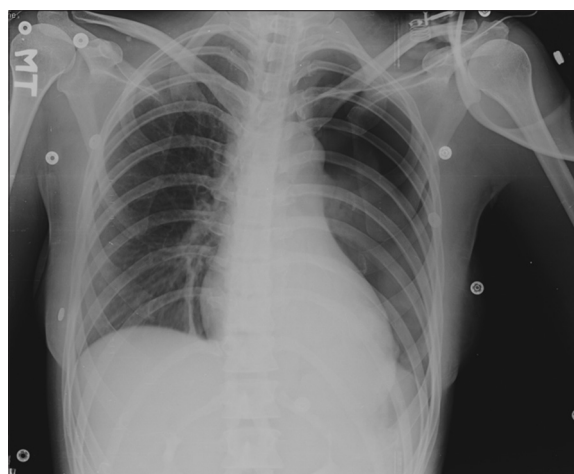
Chest X-ray of case 1. Her chest X-ray was showing bilateral nodular opacities with possible lesions in the upper and middle zones of both lungs
